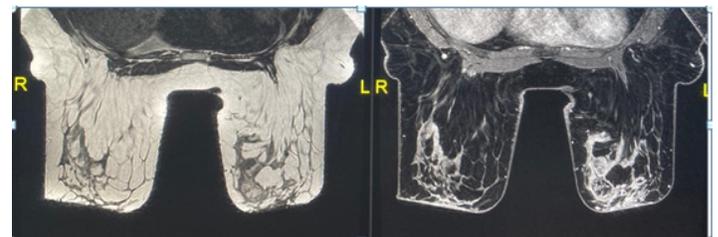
MRI-T2 WI and corresponding post contrast Fat suppressed images showing loss of signal on fat suppression with peripheral contrast enhancement—impressive of fat necrosis. Subacute stage
